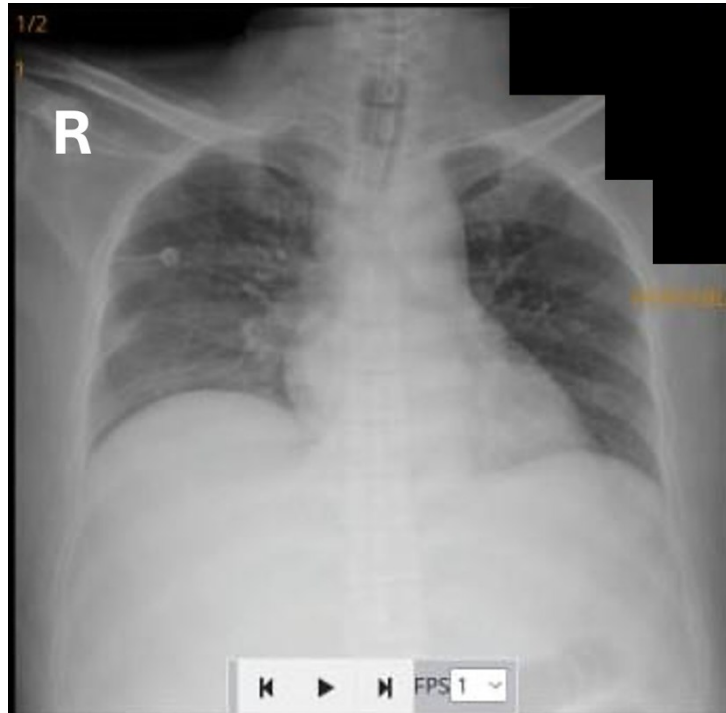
Results of the thorax X-ray examination
